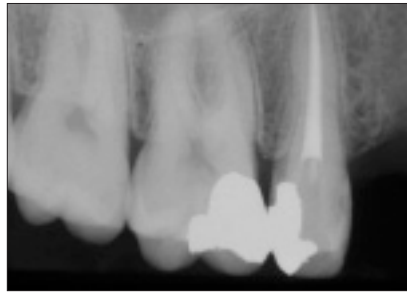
Radiographic view after completion of endodontic treatment.
